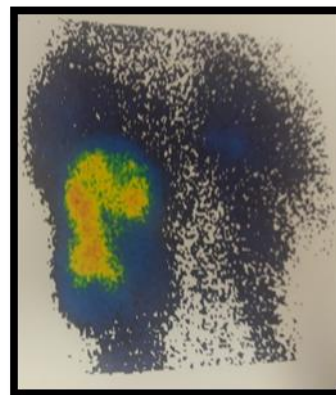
Patient's DMSA scintigraphy
